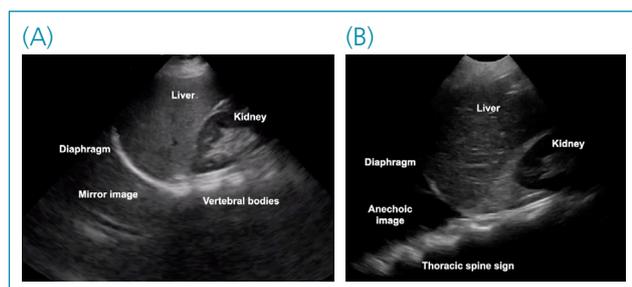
The ultrasound image obtained in the right upper quadrant. (A) Normal findings and (B) Pleural effusion is characterized by an anechoic image above the diaphragm and thoracic spine sign.
